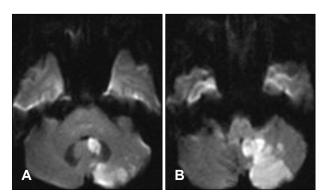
MRI finding in a patient with infarction in the territory of the medial branch of the PICA. Diffusion-weighted axial images (A and B) of the brain MRI showed an acute infarct in the left medial caudal cerebellum. PICA: posterior inferior cerebellar artery.
